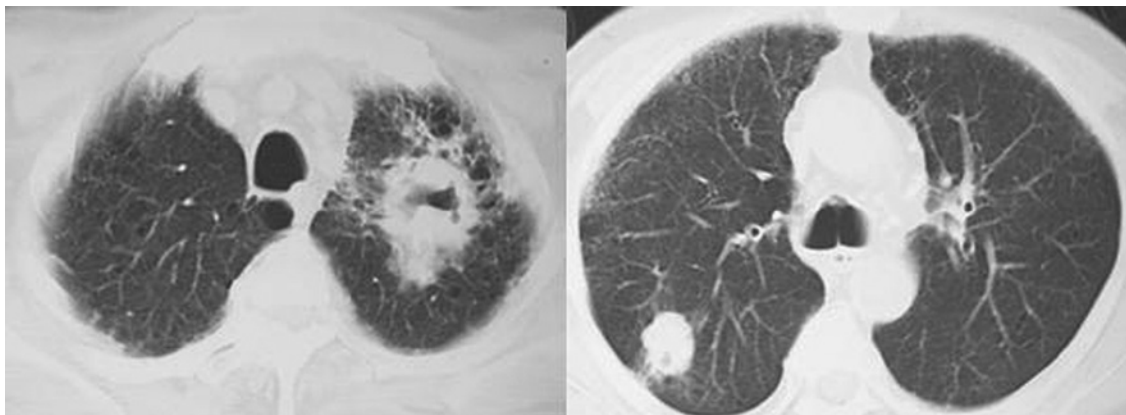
Chest CT demonstrated 2 masses located on the bilateral upper lung in patient 4. CT, computer tomography.
